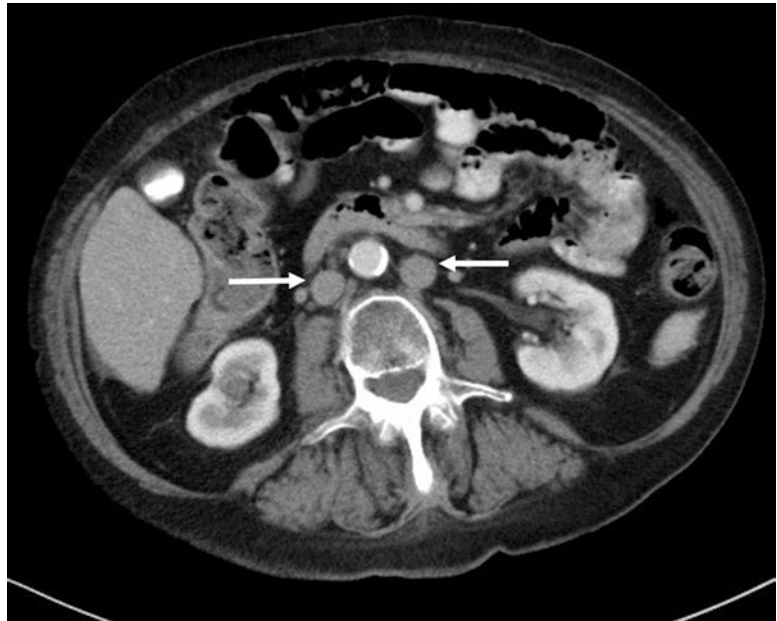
CT scan with axial views of duplicated IVC (*arrows*)
